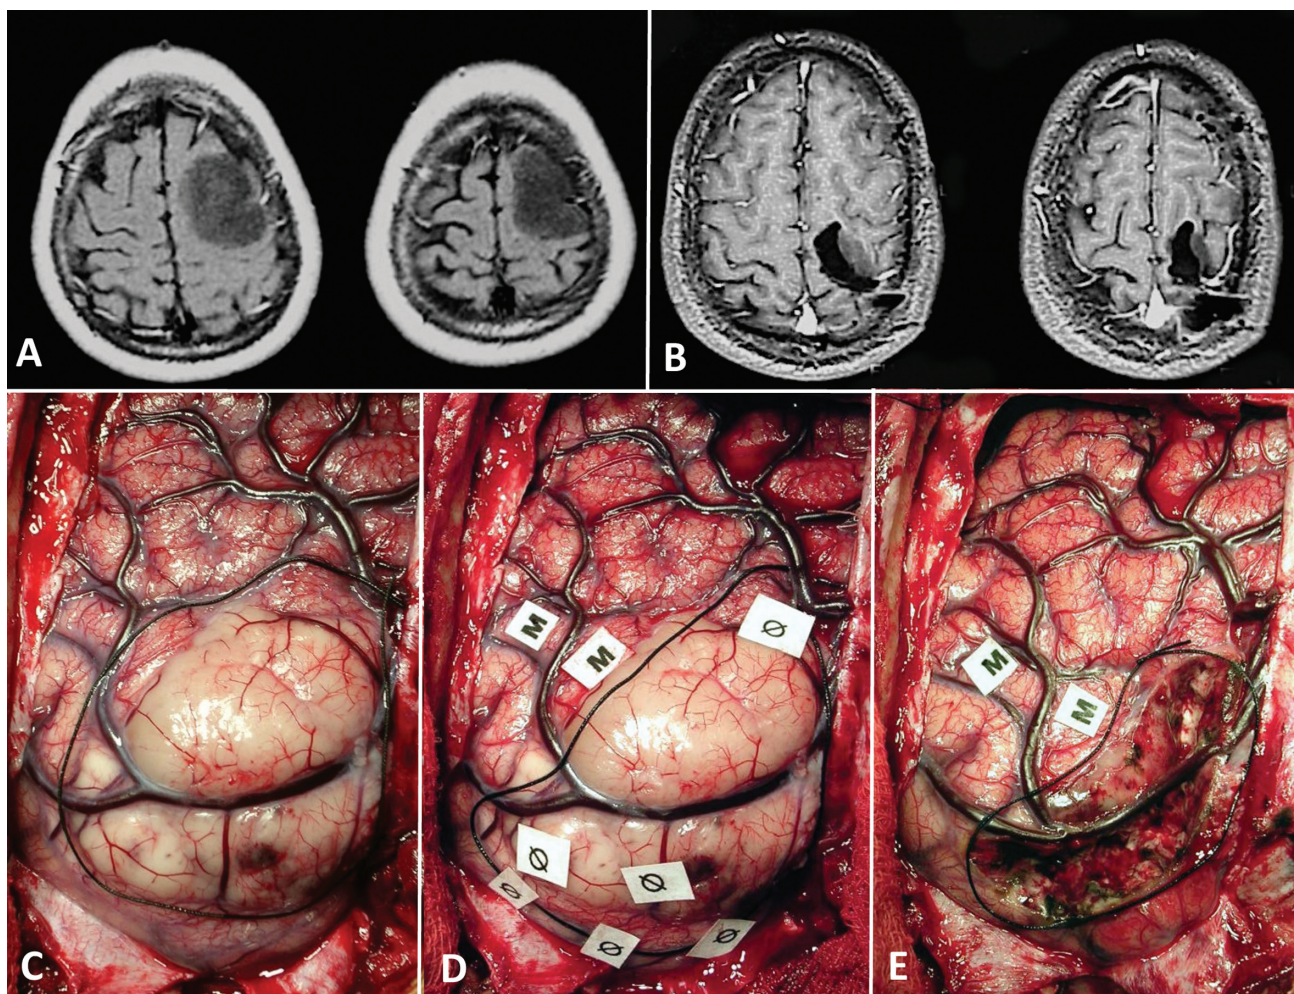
(A) Preoperative, contrast-enhanced T1-weighted MRI: Hypointense, no-enhancing, slightly insufflated image located in the left frontal region whose posterior border is close to or encompassing the motor area. (B) Postoperative, contrast-enhanced MRI showing incomplete lesion resection. The tumor residue site corresponds to the motor strip (hand). (C) Intraoperative photo prior cortical stimulation: a silk thread demarcates the planned resection area based on anatomical and imaging data. (D) Intraoperative photo after mapping: motor response (M) was obtained at anterior and lateral border of the lesion. The silk thread had to be moved medially. Ø represents areas of no response. (E) Intraoperative photo after lesion resection. It is observed that the final resection was smaller than the initially planned one. The patient had no definitive deficit.
